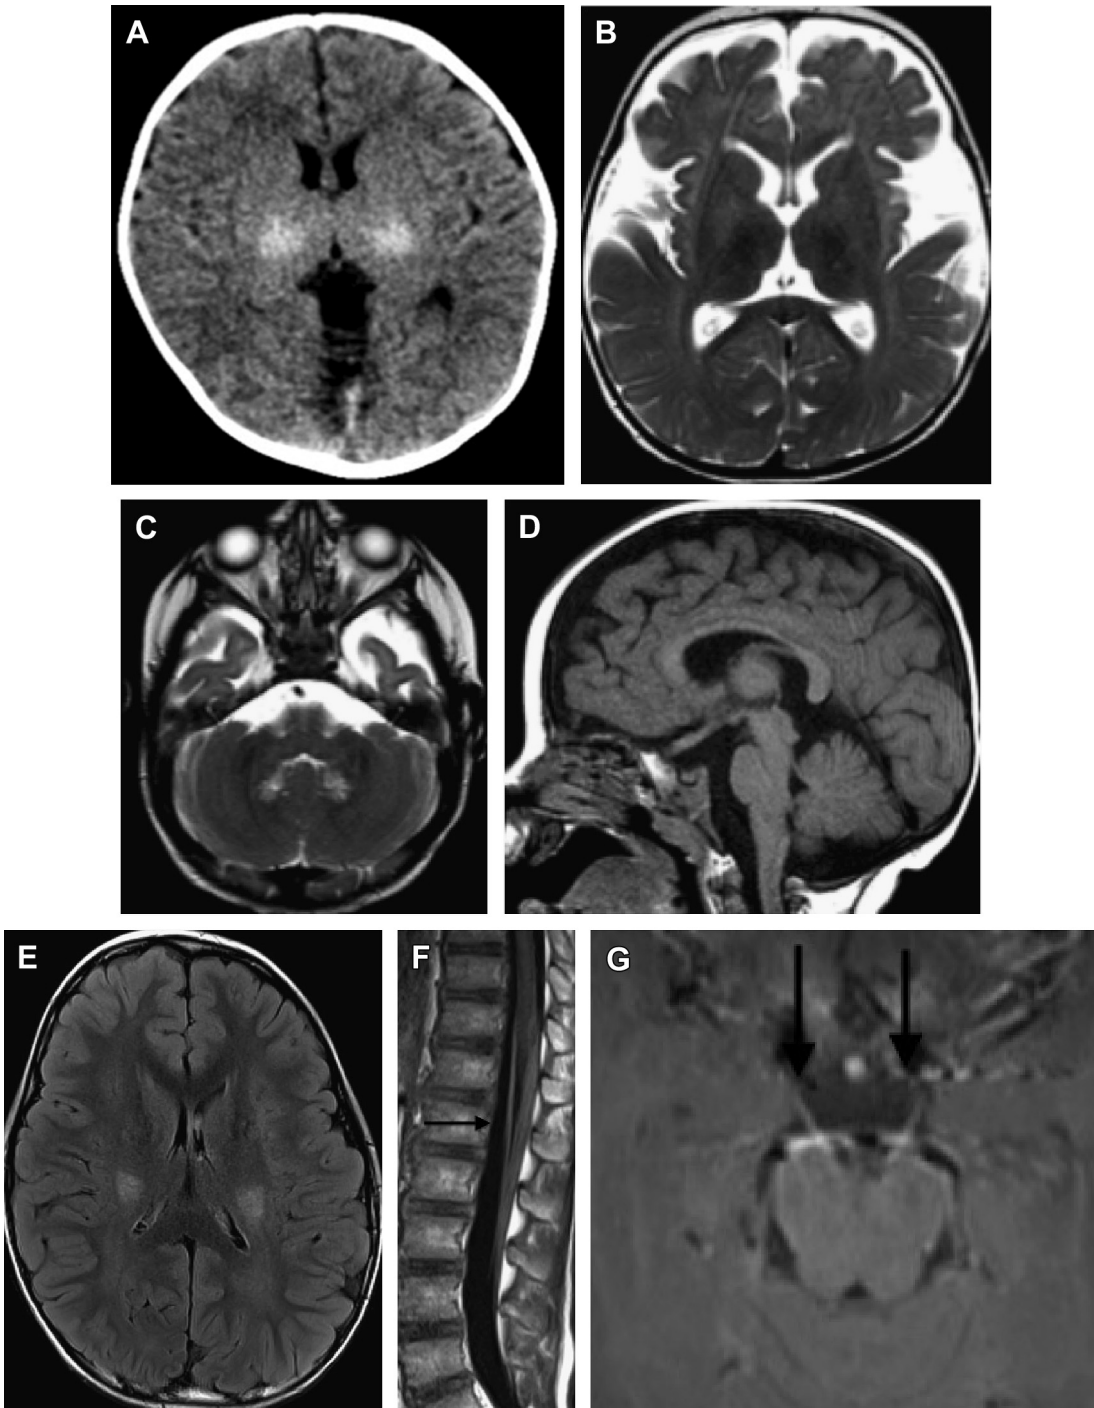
Krabbe disease. Infantile presentation in 6-month-old children with increased irritability and extremity hypotonia: Axial computed tomography (A) demonstrates hyperdensity of the thalami. Axial T2-weighted images (B, C) demonstrate hypointensity of the thalamus as well as dentate nucleus signal increase and suggestion of corticospinal tract signal increase. Sagittal T1 (D) images demonstrate thickening of the optic nerves. Although the opercula are unusually prominent, the thickening of the optic nerves and the dense appearance of the thalamus suggested Krabbe rather than glutaric aciduria I, which was also considered. Juvenile presentation of Krabbe in a 6-year-old with motor regression: Axial Fluid attenuated inversion recovery images demonstrate signal increase in the corticospinal tracts (E). Postcontrast images demonstrate enhancement (arrows) of the cauda equina (F) and oculomotor nerves (G).
